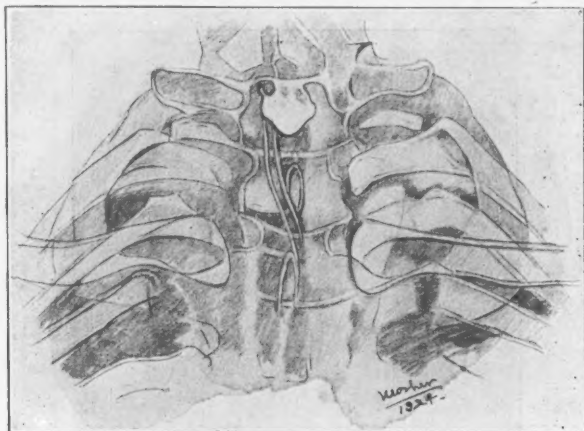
Retouched tracing from an X-ray film of a small esophageal pouch. Notice that the esophagus does not run down in line with the center of the pouch but from the left side. The supposition is that the right half of the mouth of the esophagus is obliterated. Owing to the age of the patient and because the pouch gave only slight symptoms no esophageal examination was advised. Compare with Figs. No. 13 and 27. Reduced one-half.
